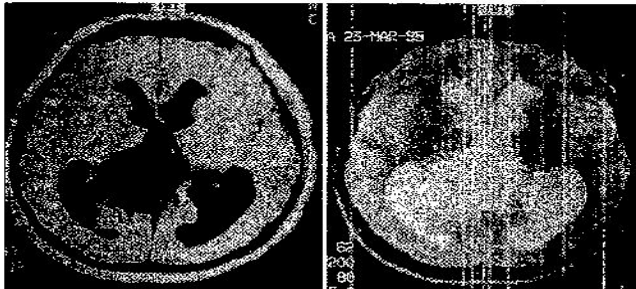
Case 6. Magnetic resonance images. *Left:* A T₁-weighted image revealing a huge, slightly hypointense dishomogeneous lesion displacing and occupying the posterior portion of the supratentorial ventricular system. *Right:* A T₂-weighted image displaying a homogeneous high signal.
